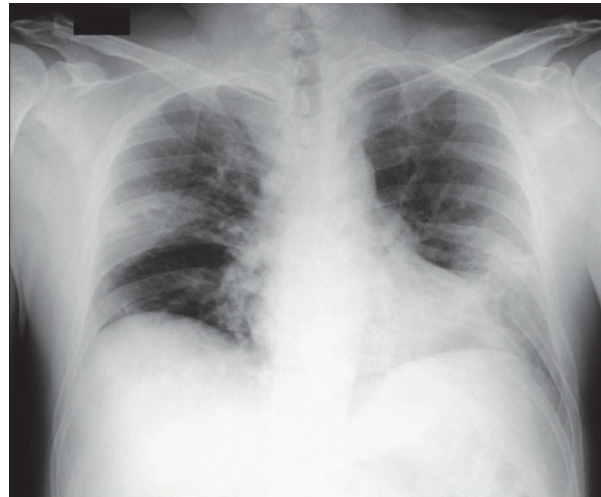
Chest x ray and high-resolution chest CT in case 1
